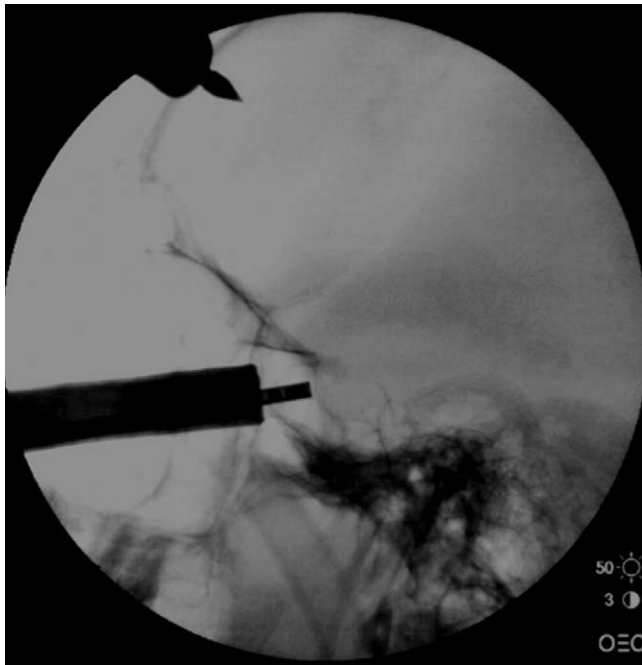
Lateral fluoroscopic radiograph shows the endoscope at the level of the sphenoid below an expanded sella.
